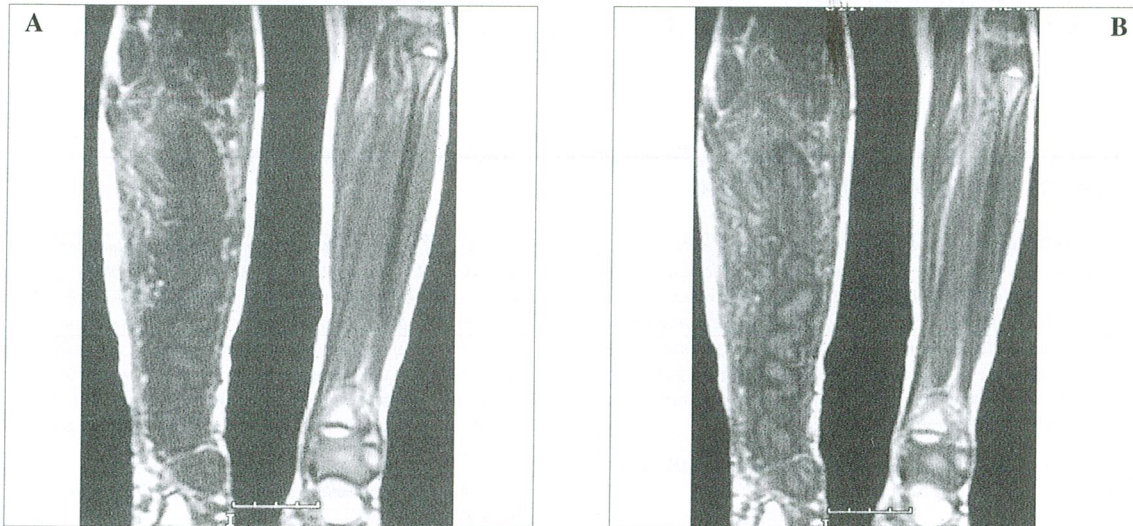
Coronal pre- (A) and postgadolinium (B) T1-weighted MR images. The central zone of the lesion shows more contrast enhancement than the peripheral regions (B).
